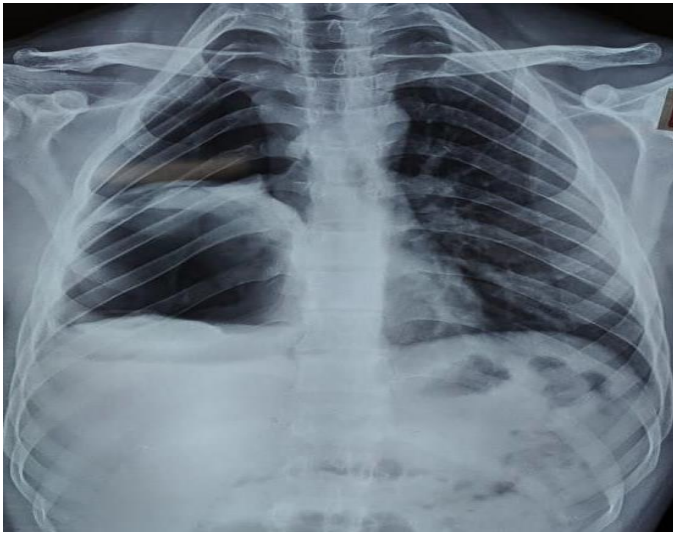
Initial X-ray suggestive of the thick walled cavitary lesion with air fluid in right lower zone of lung.
